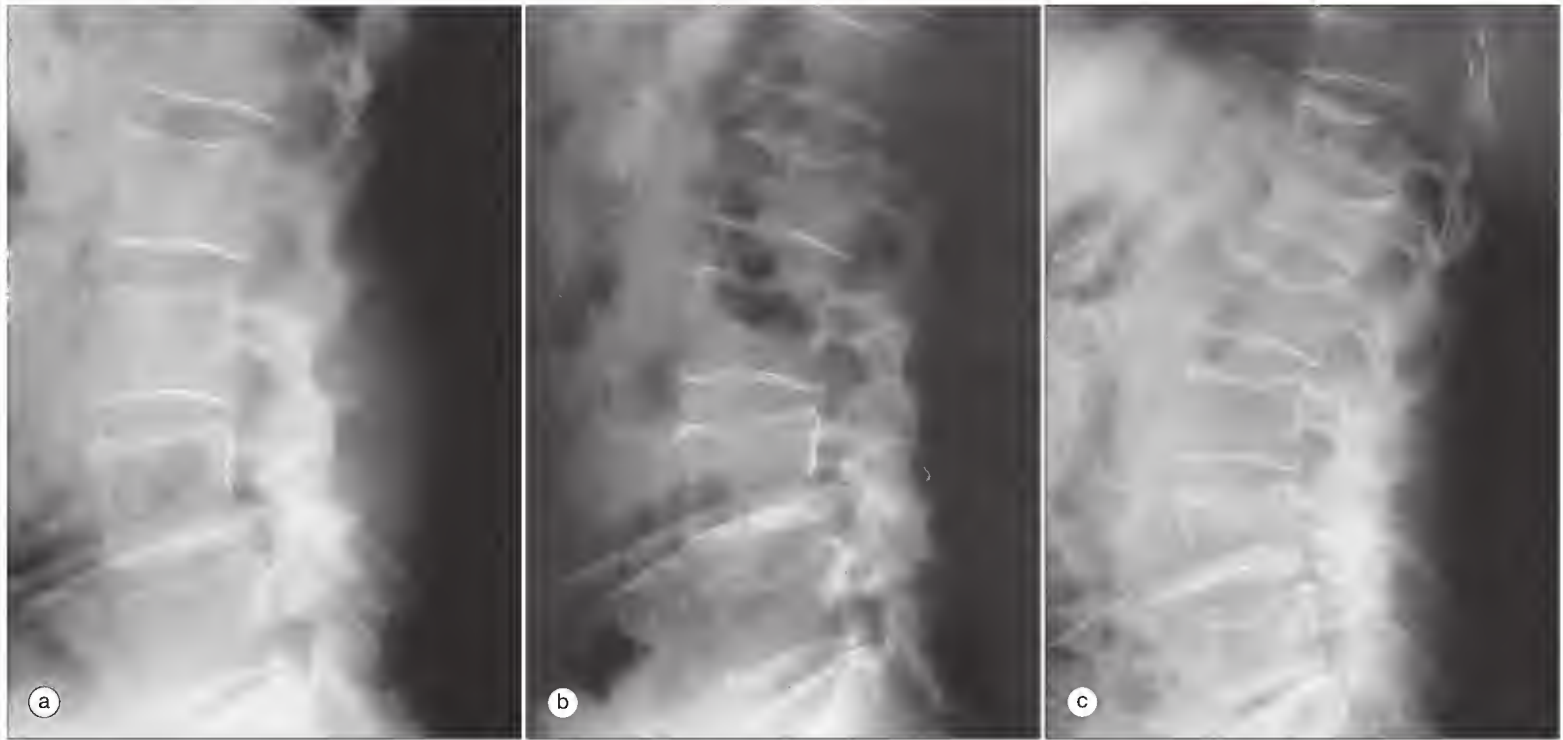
Multiple myeloma. A series of plain radiographs taken over a 3-month period show progressive osteopenia and pathologic compression fractures. (a) Initial evaluation. (b) At 12 weeks. (c) At 14 weeks. The diagnosis was made 12 weeks after the initial evaluation.
